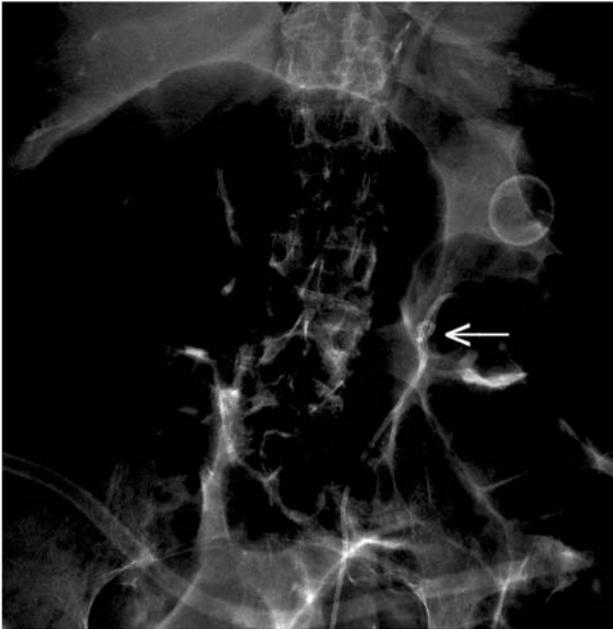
Knot formation seen on abdominal X-ray (arrow).
